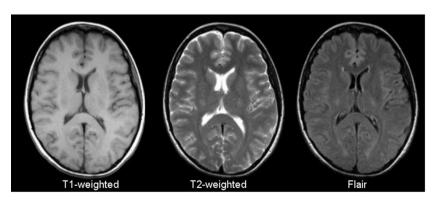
T1-, T2-weighted, and FLAIR magnetic resonance images.
